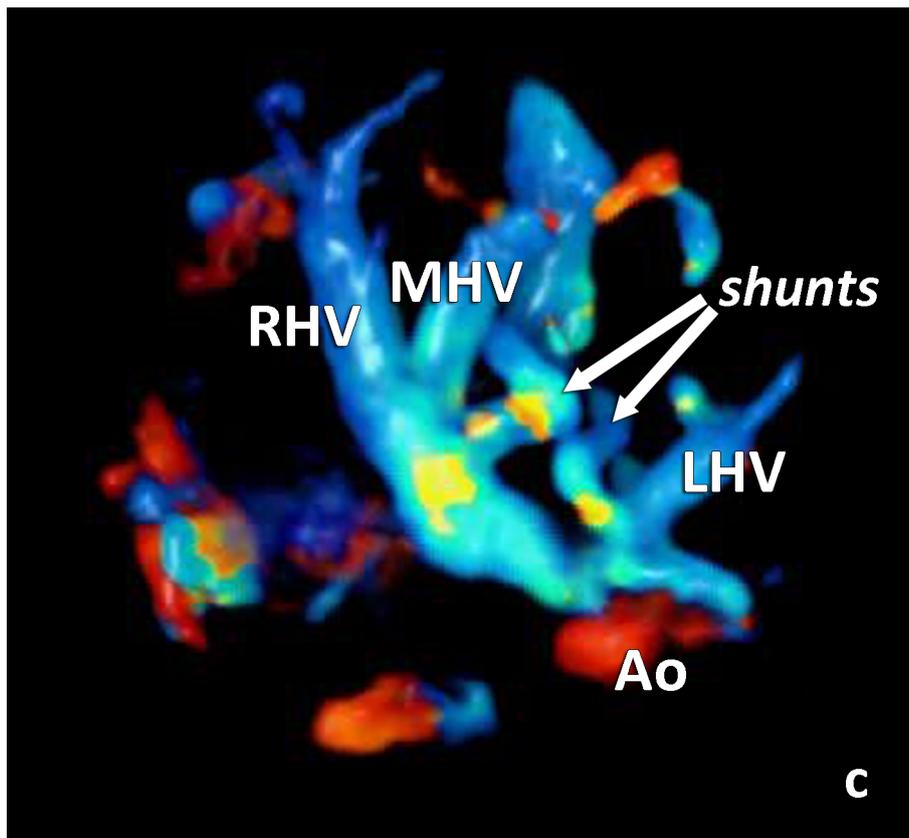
plane B new Doppler porto-hepatic shunts.tif
